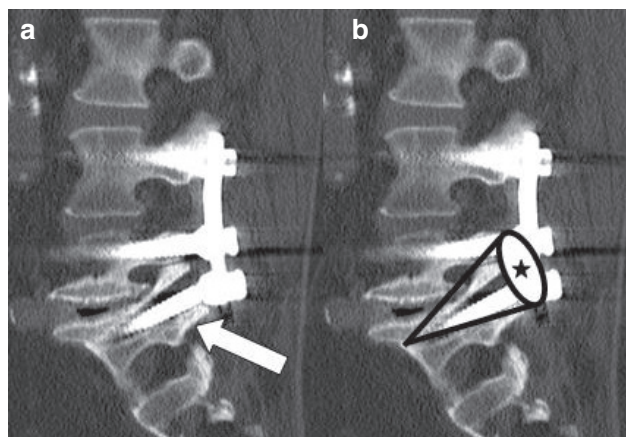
CT-scan reconstruction of a patient with a pseudarthrosis L5/S1 and screw loosening in S1 (\Rightarrow). Due to the main force direction in the flexion – extension bending the screw cavity is extremely enlarged in an elliptical shape with the maximum diameter at the base (*).
